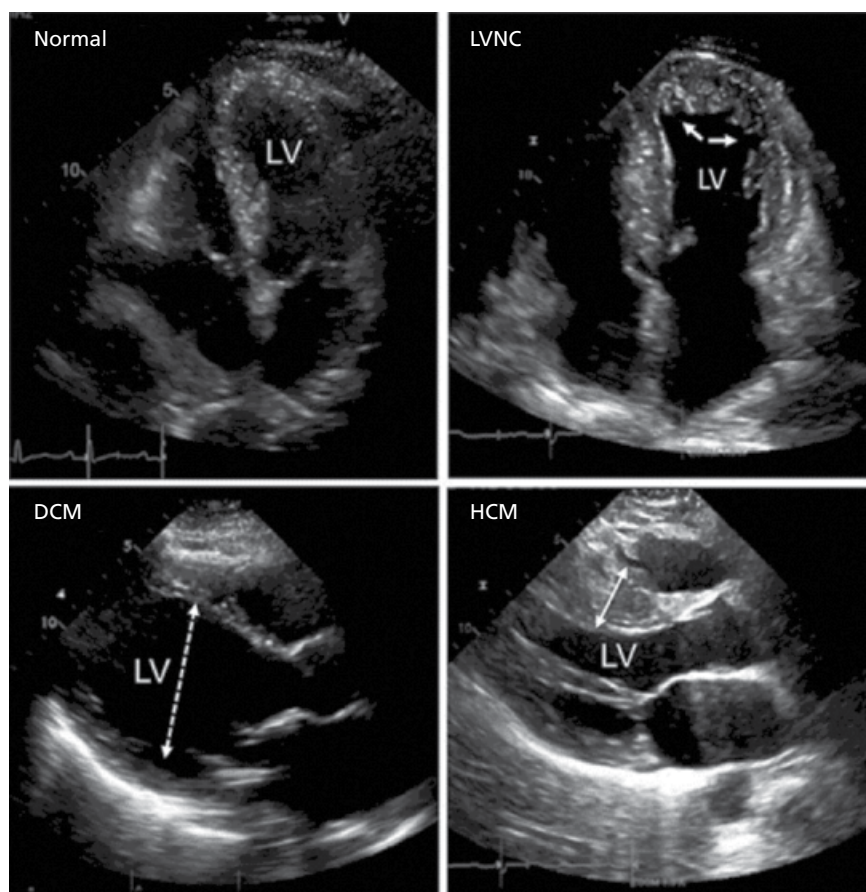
Echocardiography of the three more common forms of cardiomyopathy. Left ventricular non-compaction (LVNC) is shown in the upper right (arrows indicate deep trabeculations in the left ventricle (LV)). Dilated cardiomyopathy (DCM) is defined by enlarged LV diameters (dashed double-sided arrow). Hypertrophic cardiomyopathy (HCM) is defined with a thickened LV, including the septum (marked with double-sided arrow). Source: Reproduced from McNally and Mestroni [336] with permission of Wolters Kluwer.
